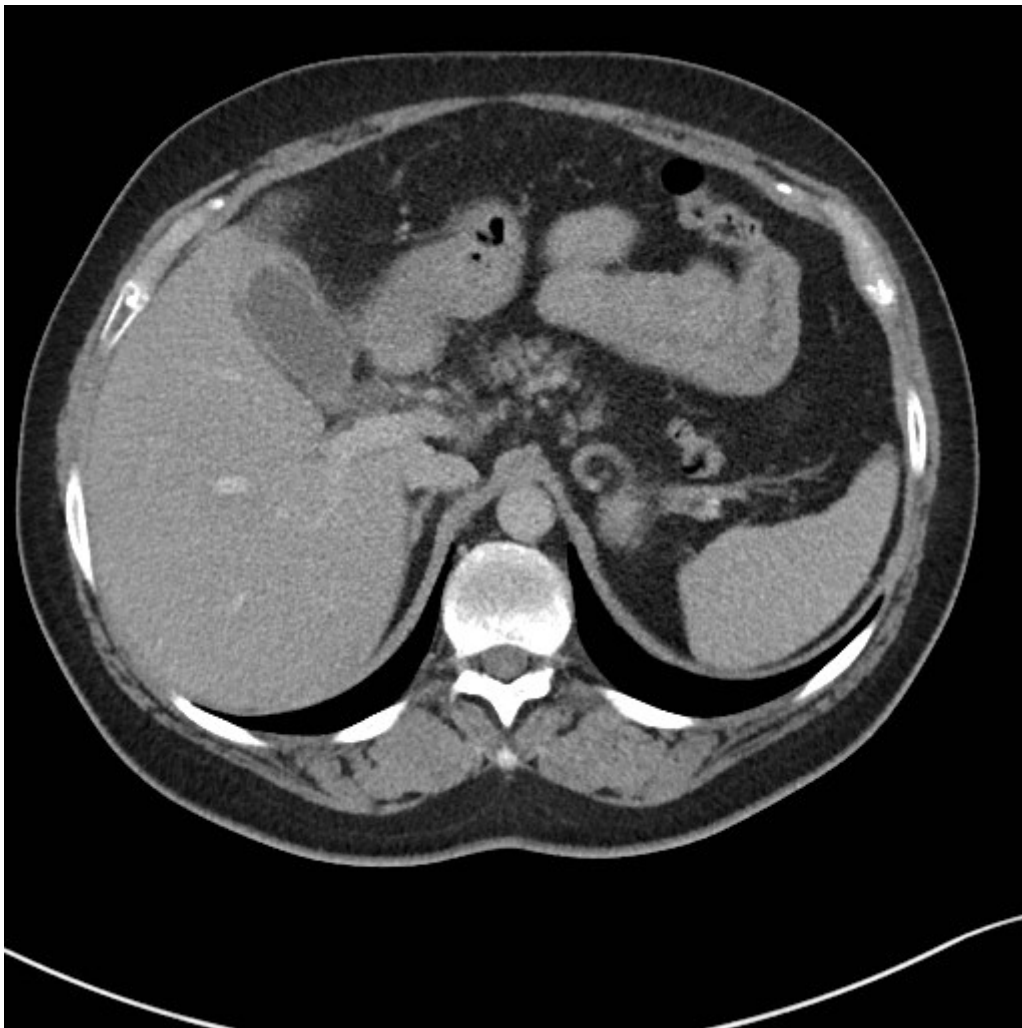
Computed tomography of the abdomen findings: acute cholecystitis.
